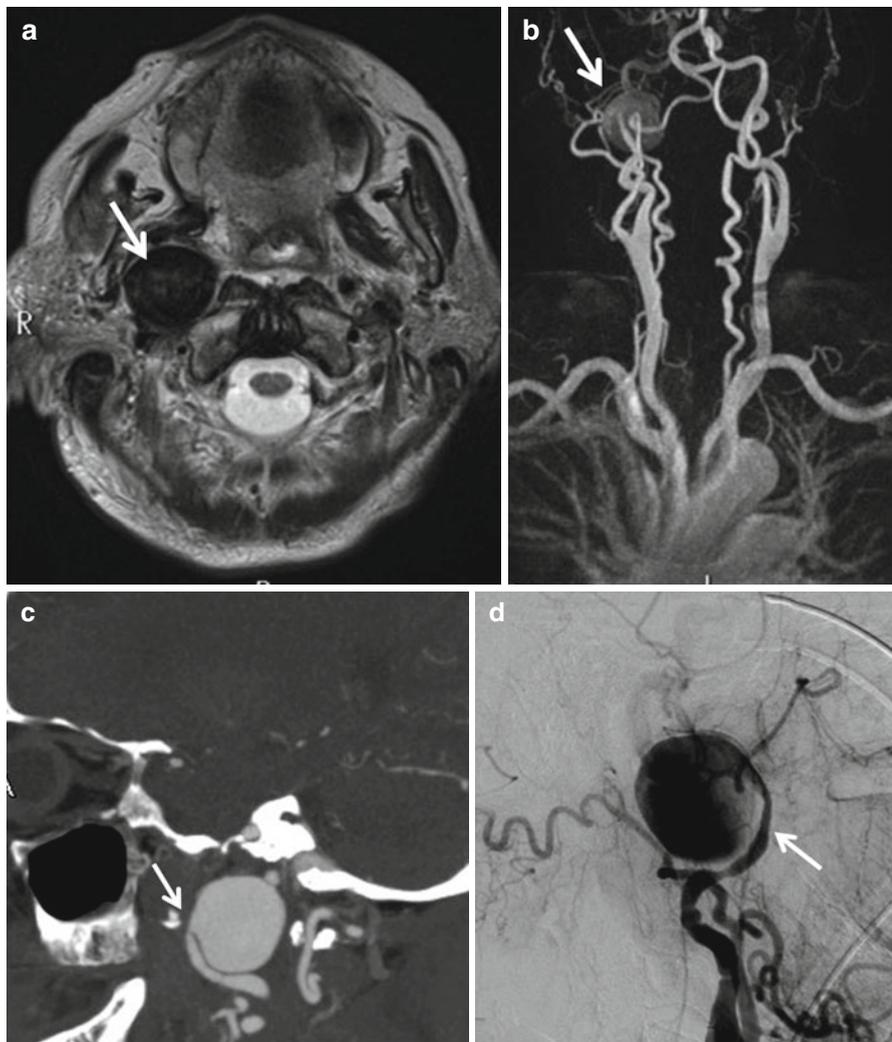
Internal carotid artery aneurysm. Axial T2-weighted MR (a) shows a T2 hypointense lesion within the right carotid space, which clearly appears to arise from the right internal carotid artery (*white arrow*) on the MR angiogram of the neck (b), CT angiogram (c), and the catheter angiogram (d)
